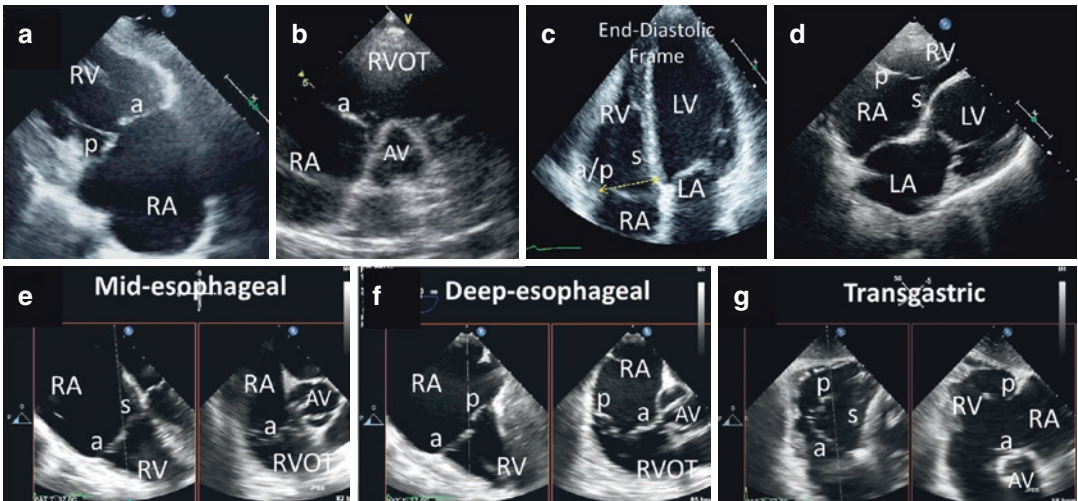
Transthoracic and transesophageal imaging planes for the tricuspid valve. Multiple transthoracic imaging planes (a to d) should be performed for comprehensive imaging of the tricuspid valve (TV). The parasternal inflow view (a) images the anterior (a) and posterior (p) leaflets when no ventricular septum is in the imaging plane. (b) Parasternal short-axis view at the level of the aortic valve; when the transducer is angled anteriorly, only the anterior (a) leaflet is seen (with no other leaflet coaptation). (c) On-axis 4-chamber view with the left ventricle (LV) in the apex of the sector. The end-diastolic frame shown should be used to measure the annular
